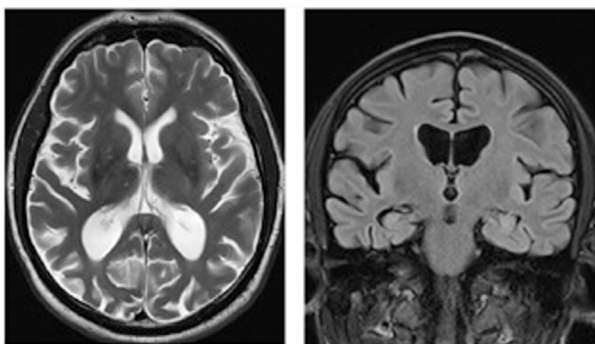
Magnetic resonance images (axial T2, coronal FLAIR) of a patient with posterior cortical atrophy demonstrating marked regional atrophy in the occipitotemporal regions and relative preservation of the hippocampi. Patient under the care of GTP; published with patient's authorization.
